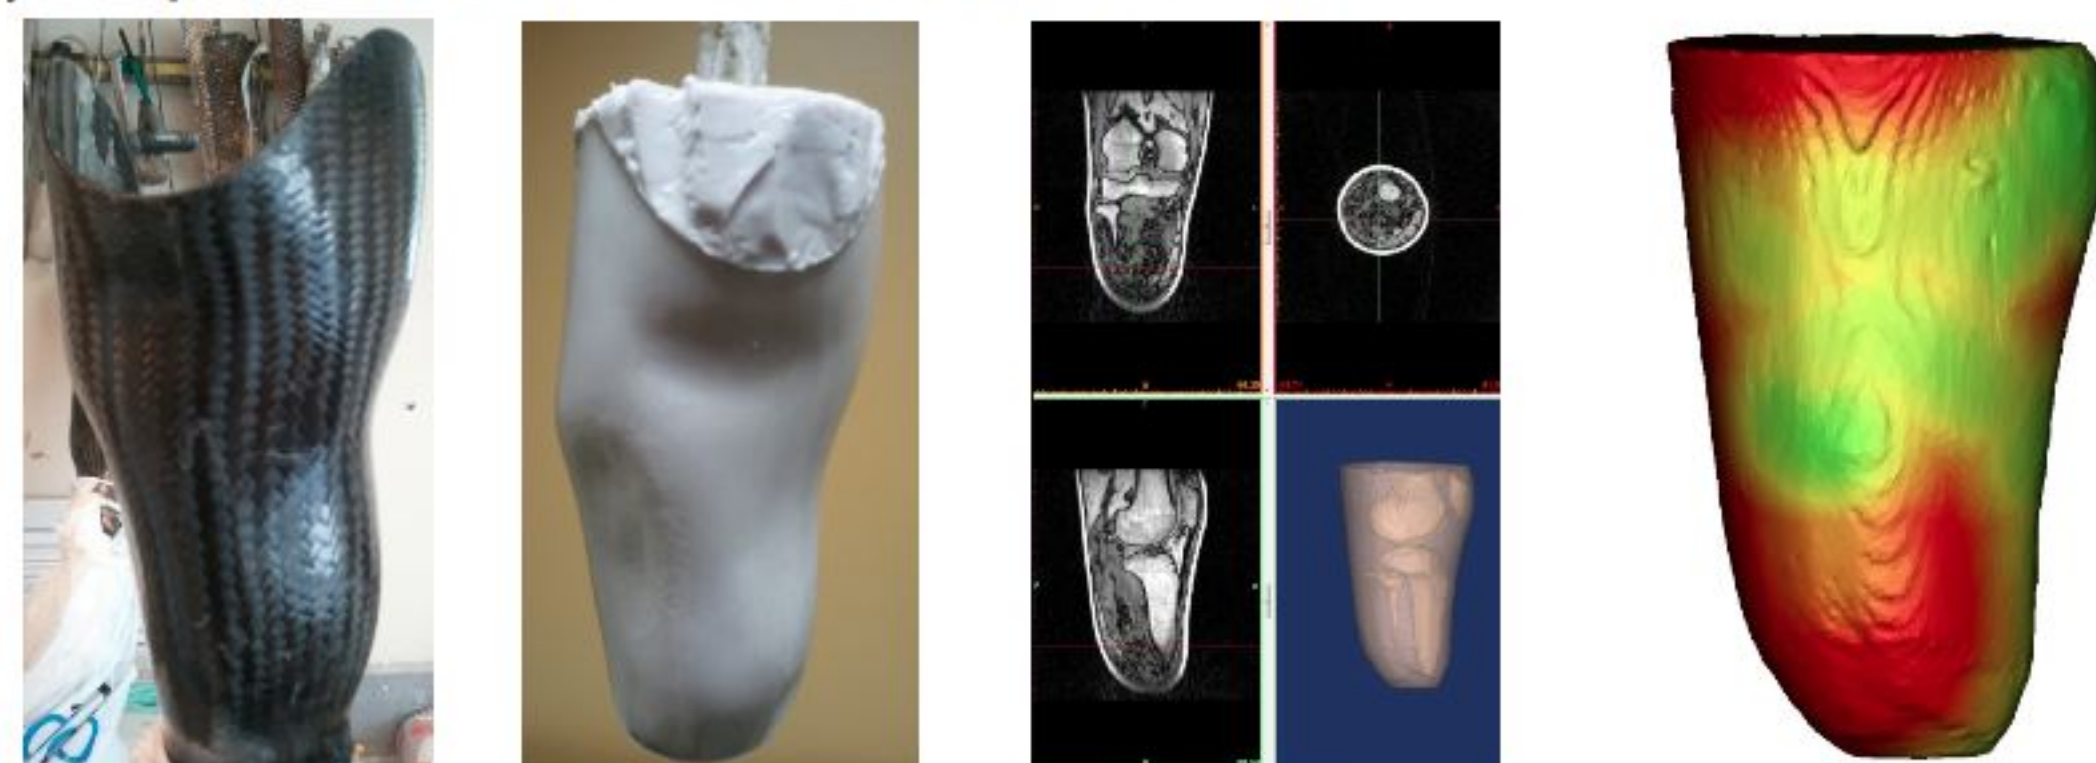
(Left - Right) Participant's conventional carbon fiber socket, male plug of conventional socket, MRI capture of residual limb, soft tissue density of residual limb.
